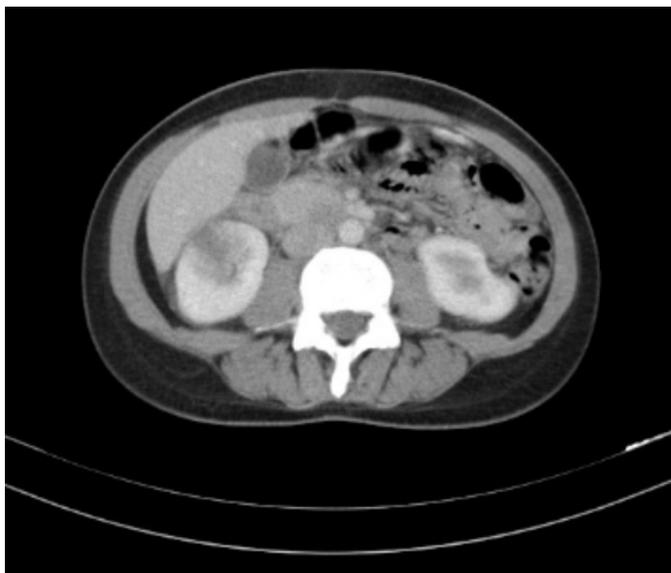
Typical acute lobar nephronia abdomen computed tomography image of the right kidney
